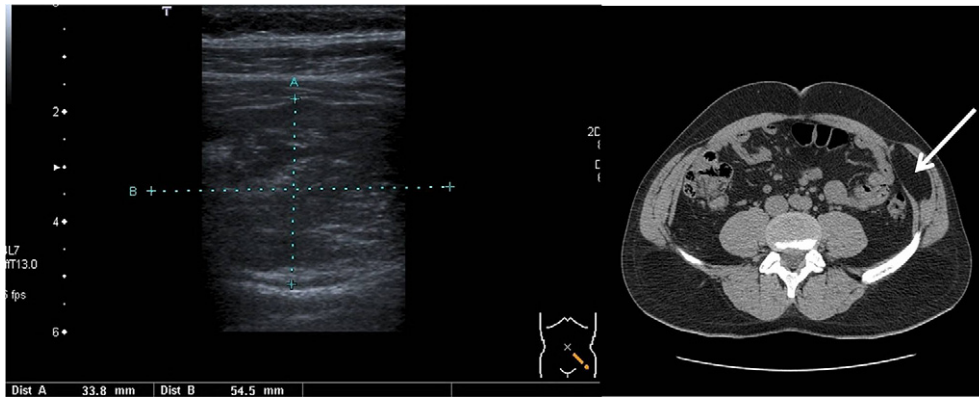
Transverse section ultrasound, using a high-frequency linear probe, of the abdominal wall showing a well-defined, slightly hypoechoic lesion with features suggestive of a lipoma. Low density at CT examination confirmed the diagnosis.
